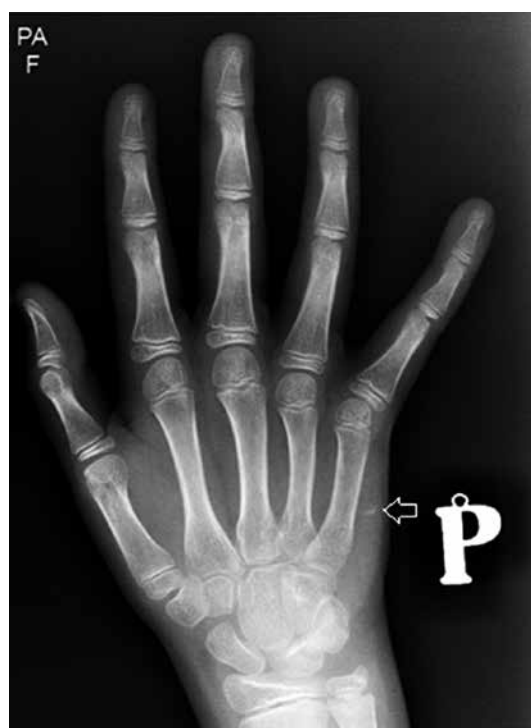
A foreign body is seen in the X-ray (arrow)
